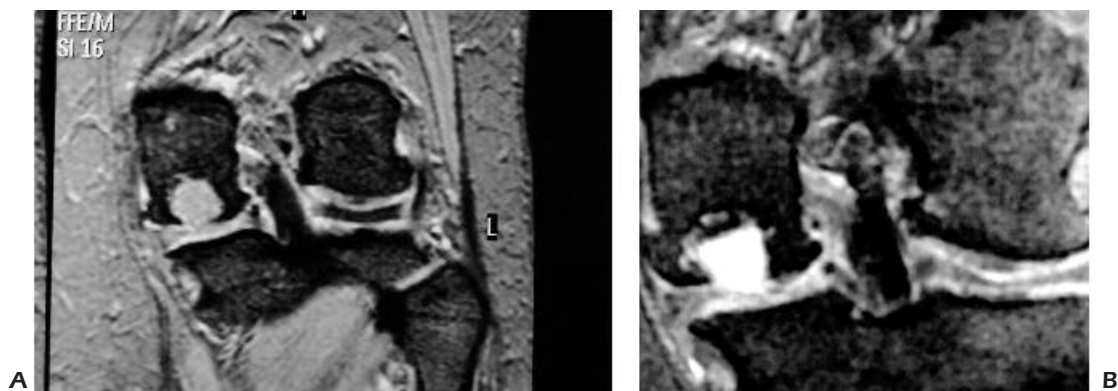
50 year old female with 10 mm IV degree defect on the weight bearing area of the left medial central condyle A, and B, MRI images at 12 and 96 months post-implantation. MRI at 96 months shows implant fixed and no abnormalities. Patient recovered completed knee functionality and stability and is pain free. IKDC: from 19 points pre-op to 87 points at 96 months post-op.
